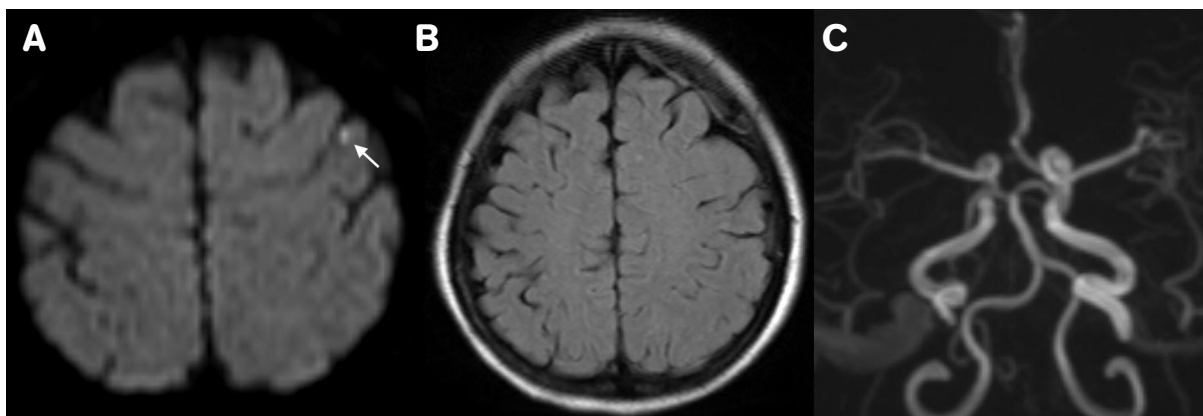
(A) The diffusion weighted imaging (DWI) showed a bright spot in the left superior frontal gyrus (arrow). (B) The Fluid Attenuated Inversion Recovery (FLAIR) did not show a corresponding signal change. (C) The magnetic resonance angiography (MRA) did not show segmental vasoconstriction.
